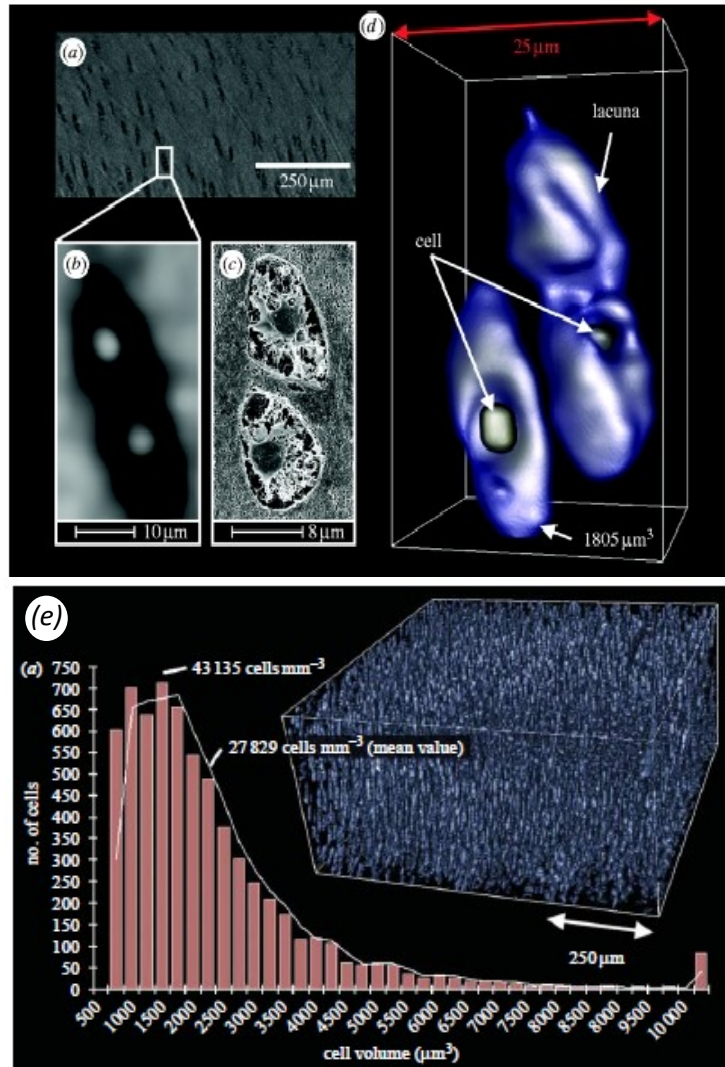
Images showing cellular information from the frontal lacuna in the soft tissue of an articular cartilage: (a) original slice image from inline PC- $\mu$ CT ; (b) magnified region of interest containing lacuna doublet with chondrocytes in the centres; (c) corresponding SEM image ; (d) 3D rendering of (c); and (e) quantitative analysis of cell density from inline PC- $\mu$ CT (adapted from [257]).
